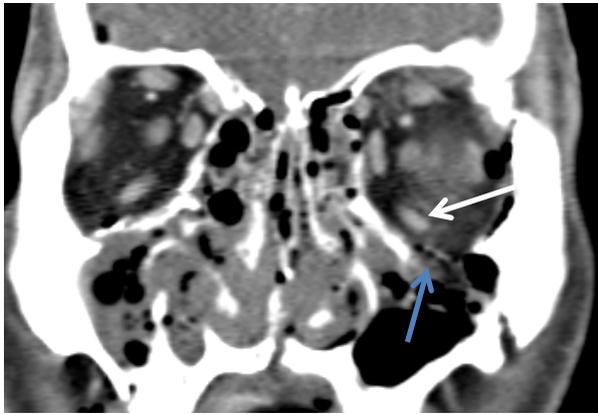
Extraocular muscle dislocation, left eye (27-year-old male after fall with a restriction of lowering the left eye). CT, coronal section: Diverse fractures of both orbital cavities with dislocation of left inferior rectus muscle (white arrow) due to orbital floor fracture (blue arrow). The orbital floor functioned as abutment.
